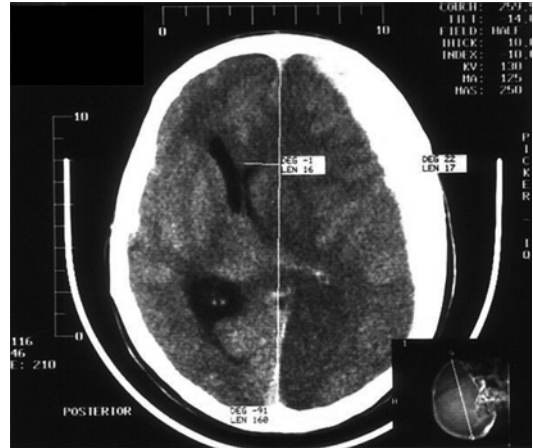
CT image of a lateral herniation caused by subdural hemorrhage
